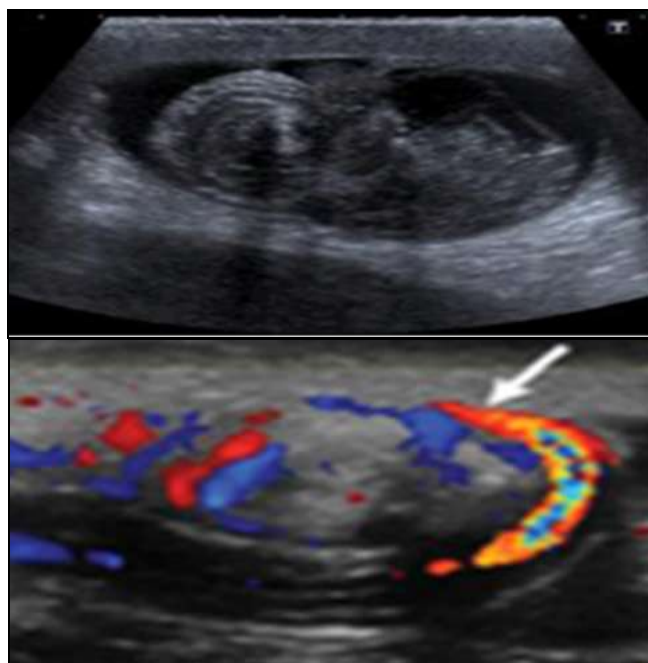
& 1B: Grey Scale and Doppler Ultrasound Images showing Sonological Whirlpool Sign
